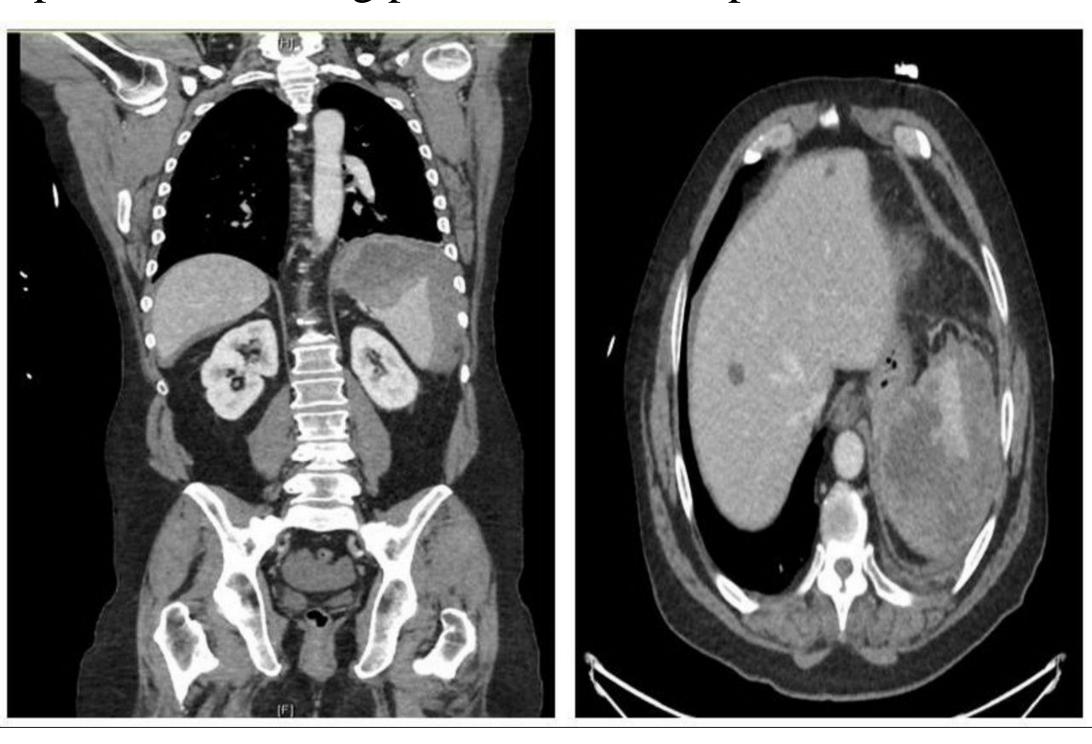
Spontaneous splenic rupture seen on CT of a patient after receiving pegfilgrastim. The spleen is noted to be significantly enlarged, and has areas of hemorrhage noted.
